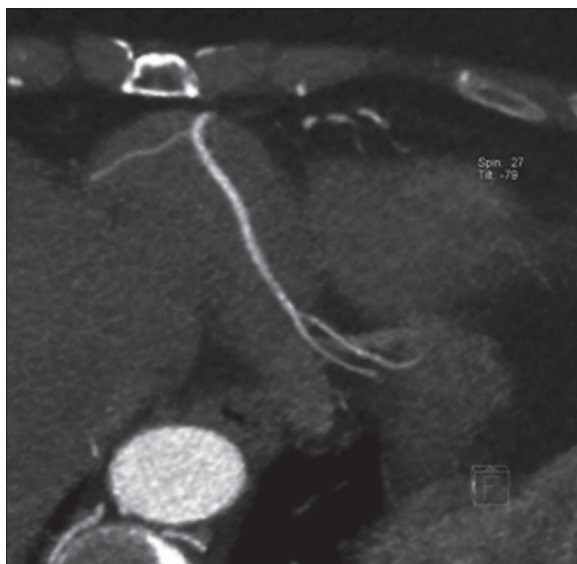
Cardiac CT. Maximum intensity projection (MIP) image shows the intra-atrial portion of the distal right coronary artery.
